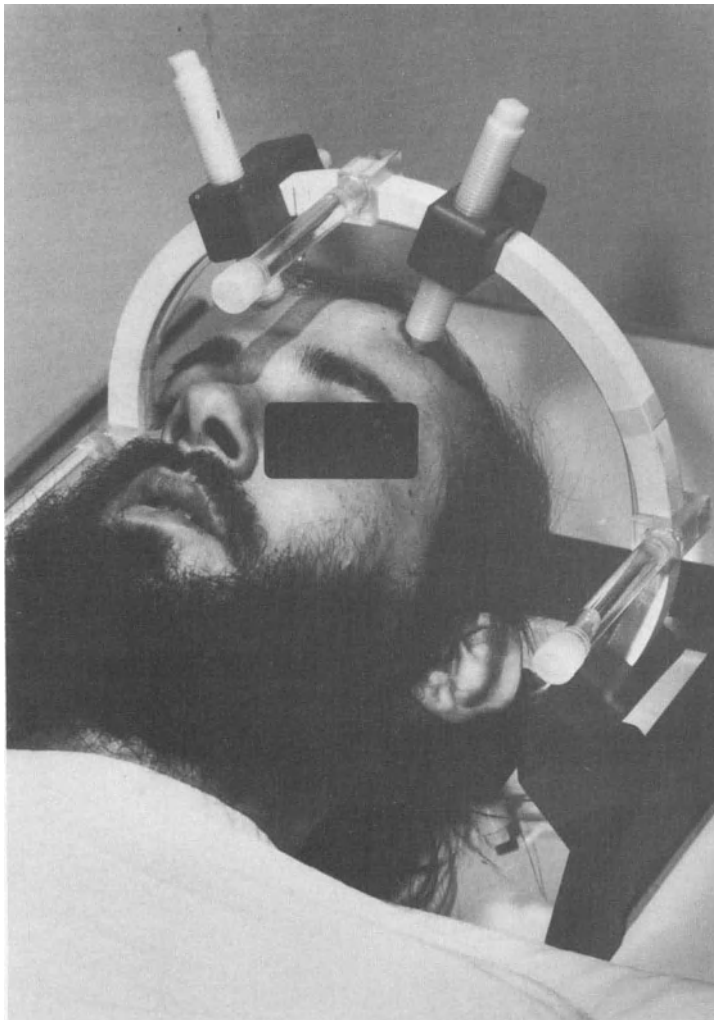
MRI stereotactic device developed by Mundinger and Birg et al. [7]. The stereotactic ring and the fixation screws are made from a special plastic material. Small steel pins which do not disturb the MRI process are attached to the tip of the screws.
